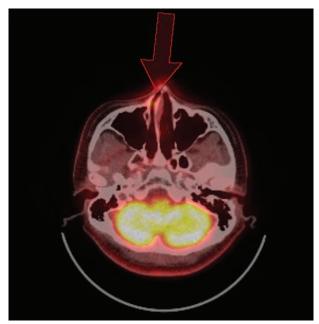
PET-CT shows a focal hypermetabolic lesion (arrow) on the right inferior turbinate. PET-CT = positron emission tomography-computed tomography.
